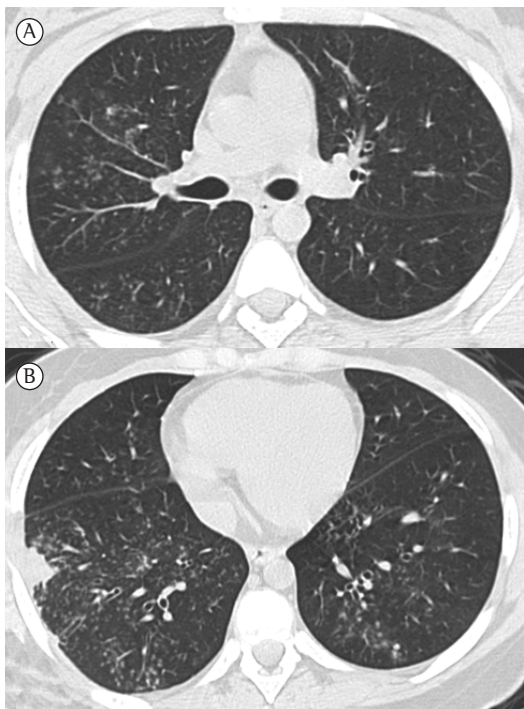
Axial HRCT slices at the levels of the upper lobes (A) and lower lobes (B) revealing multiple small centrilobular nodules, some of which have a tree-in-bud pattern, distributed principally in the middle lobe and lower lobes. Note also bronchial wall thickening predominantly in the right lower lobe, as well as a small area of peripheral consolidation.
